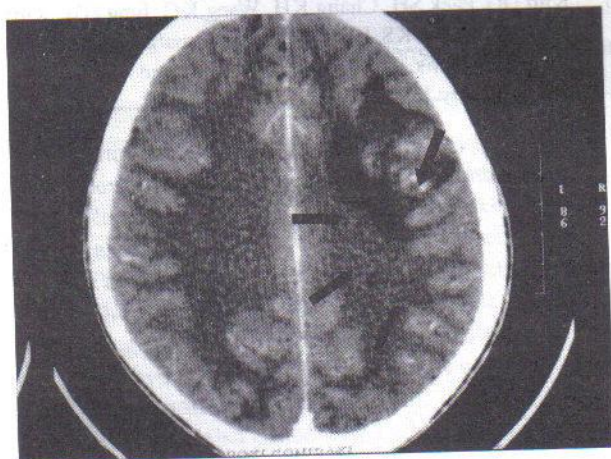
Contrast enhanced CT brain image shows minimal enhancement of the lesion.
